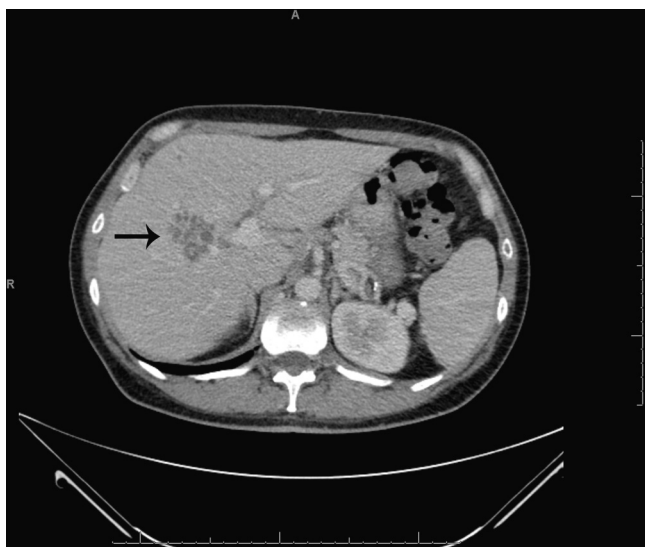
Computed tomography showing the central hepatic abscesses (arrow)
